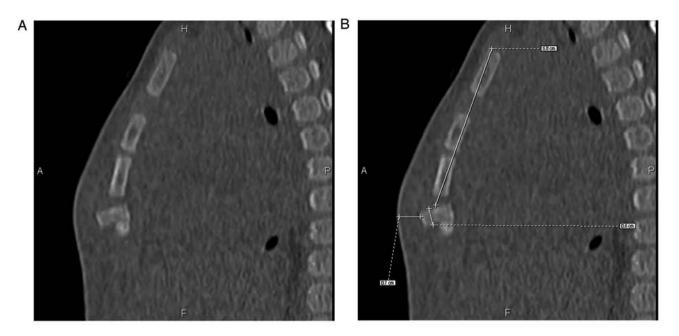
Preoperative CT findings in case A. (A) Multiplanar reconstruction image indicating that the 4th sternebra was rotated 90° forward, its margin was rough and the density of the bone cortex was decreased. Soft-tissue swelling of the anterior chest wall was seen. (B) CT measurements: The distance between the suprasternal fossa and the site of dislocation was \sim 5.8 cm; the thickness of the sternal lesion was \sim 0.6 cm and the depth of the skin incision to the sternal lesion was \sim 0.7 cm. A, anterior; H, head; P, posterior.
